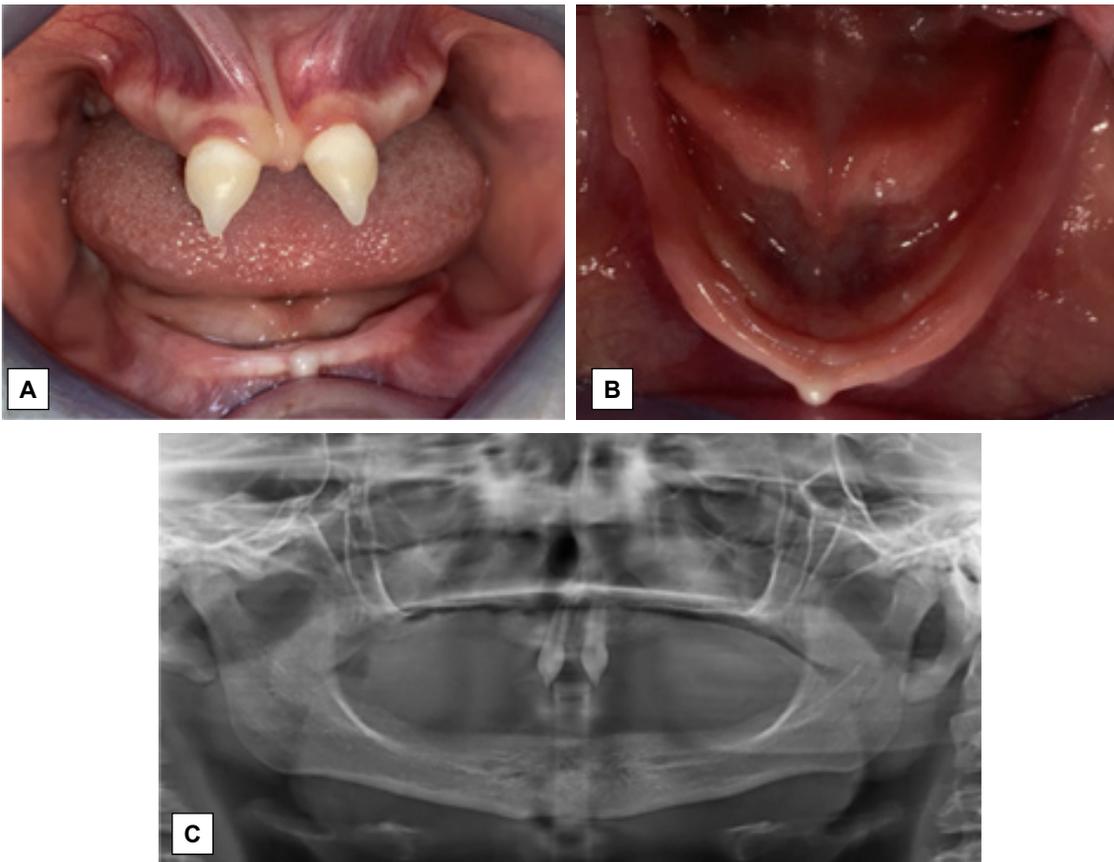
A) Intraoral preoperative view of the maxilla, B) Intraoral preoperative view of the mandible, C) Panoramic radiograph
